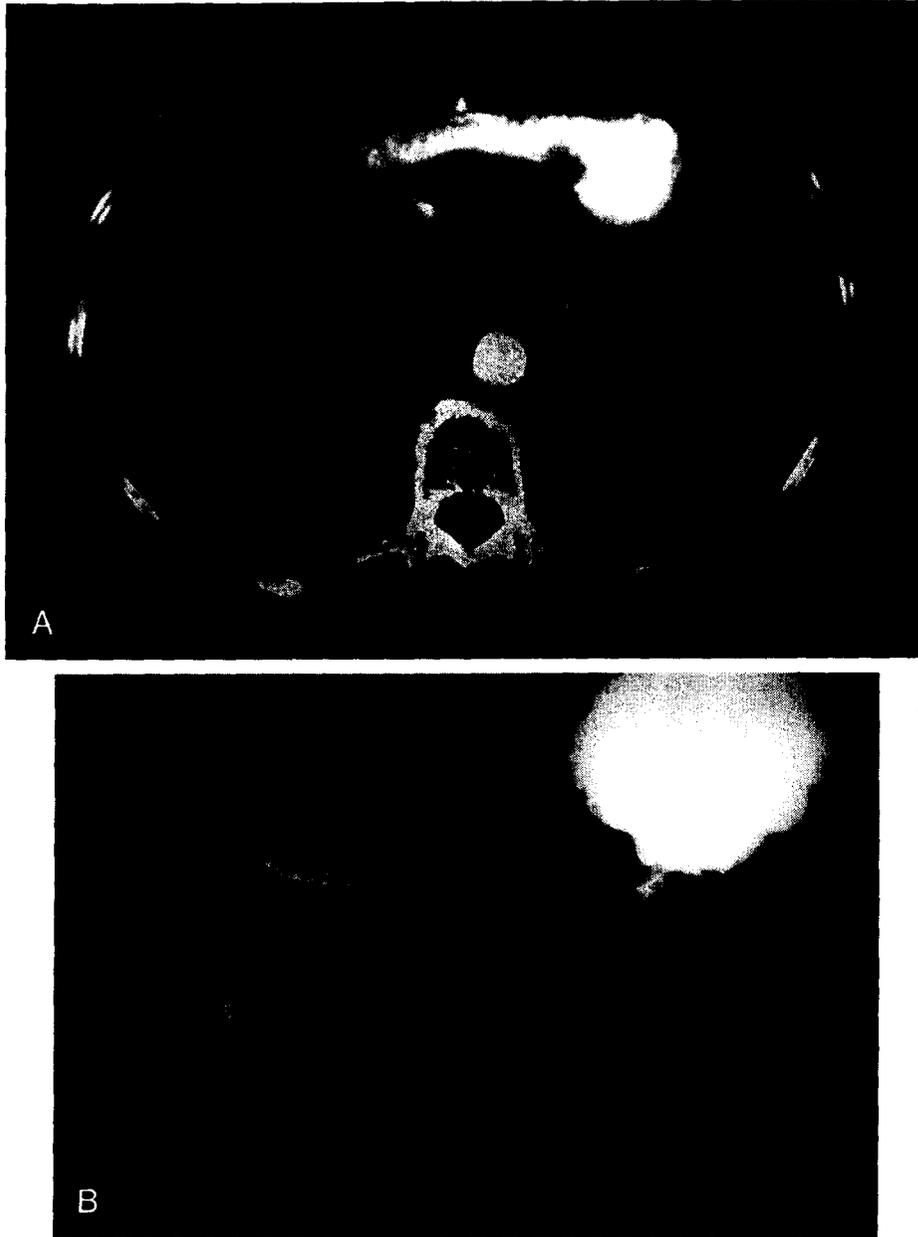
Concurrent palliation of gastric-outlet and biliary obstruction in 76-year-old woman in whom gallbladder carcinoma had been diagnosed 5 months earlier. *A*, The patient developed jaundice, nausea, and vomiting 1 week prior to her CT scan, which showed a large mass occupying most of the left liver lobe and encroaching the distal antrum and proximal duodenum. *B*, The patient underwent an ERCP, during which two self-expanding metallic Wallstent stents were placed: a biliary stent (diameter 10 mm) to alleviate stenosis of the common hepatic duct, and an enteral stent (diameter 20 mm and length 90 mm) to relieve stenosis of the antrum and duodenum. Her jaundice resolved and she went home able to eat a regular diet.
